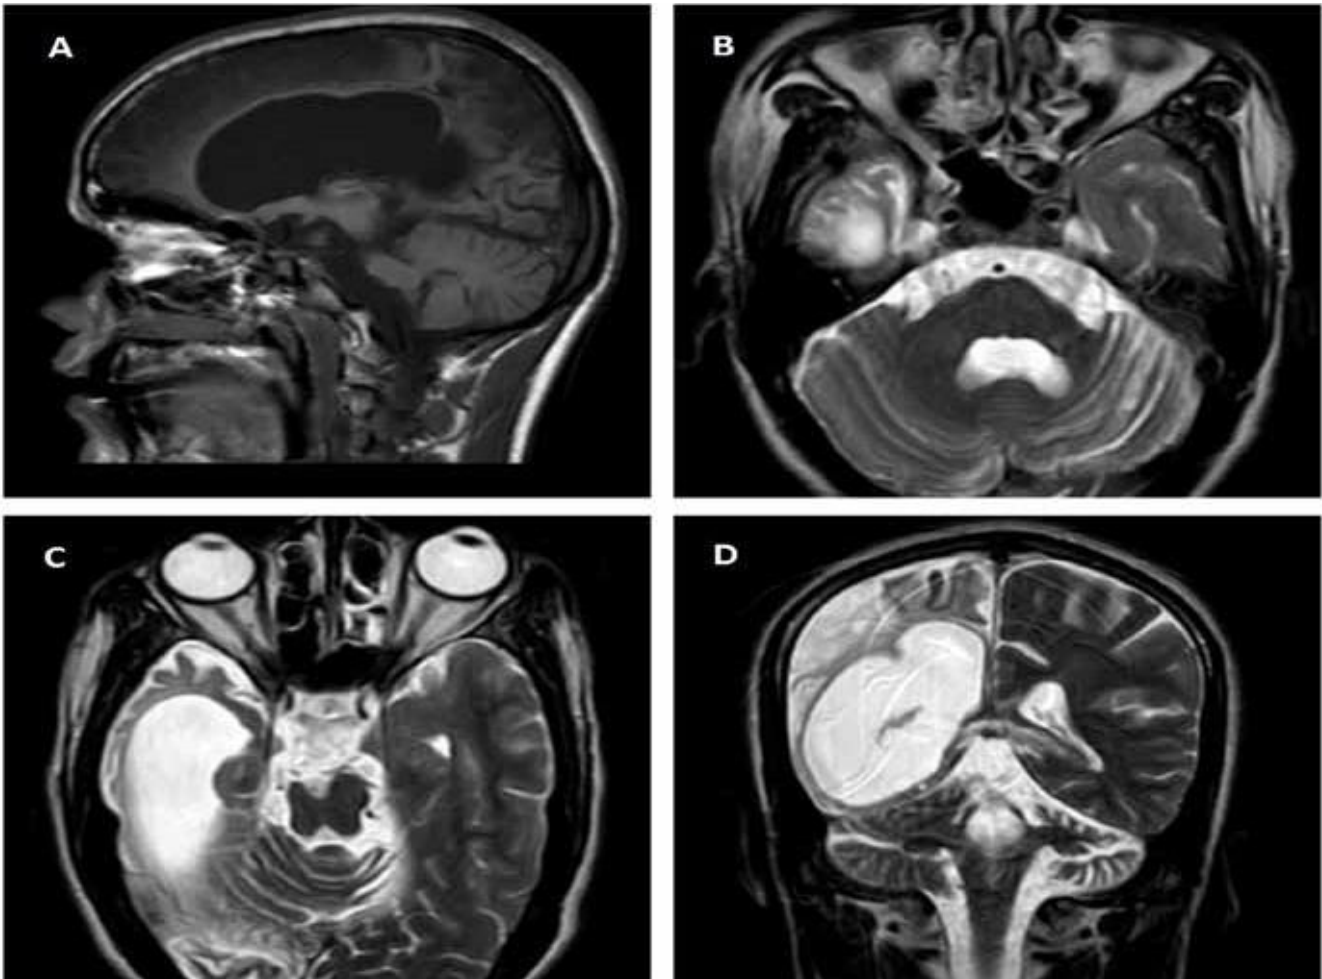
A).T1 weighted image in the sagittal plane shows calvarial thickening in the right frontal region of the skull. B).T2 weighted image in the axial plane shows an atrophic left cerebellar hemisphere with prominent cerebellar folia. C).T2 weighted MRI image in the axial plane demonstrates atrophy of the midbrain on the right side. Dilated temporal horn of the right lateral ventricle is also noted. D).T2 weighted image in the coronal plane demonstrates atrophy of the right cerebral hemisphere and contralateral (left) cerebellar hemisphere
